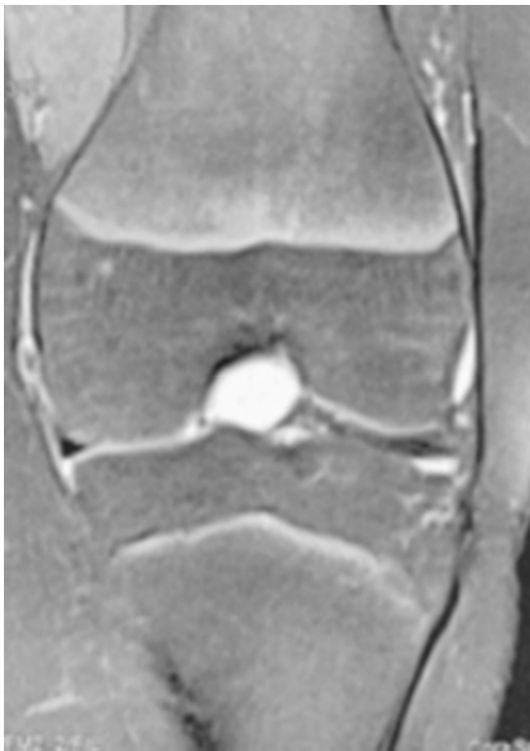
Frontal MRI showed a 33 cyst on depends of the cruciate ligament.
